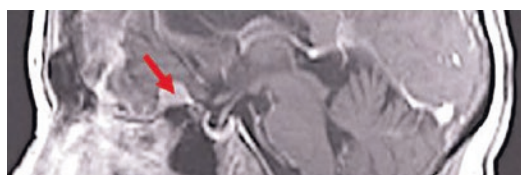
MRI scan (T1 sequence) with contrast—mid-sagittal view. Red arrow denotes lesion
